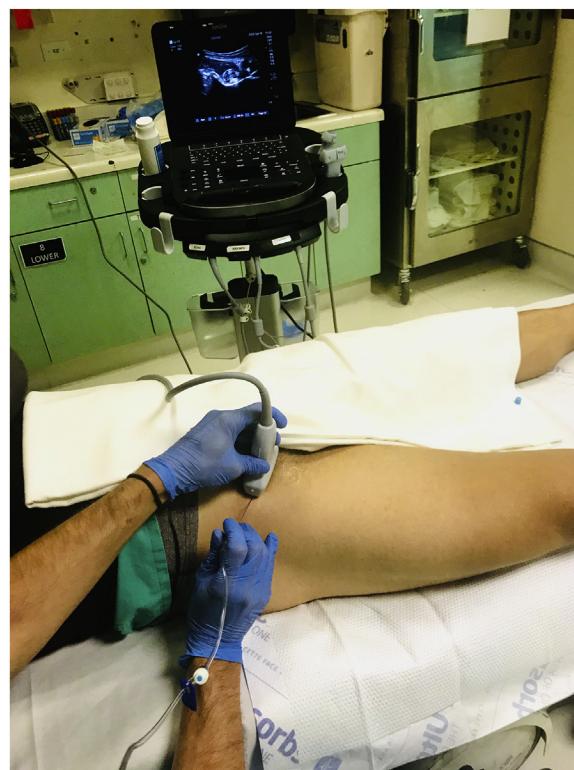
Patient, provider, and ultrasound system positioning for a PENG block.
